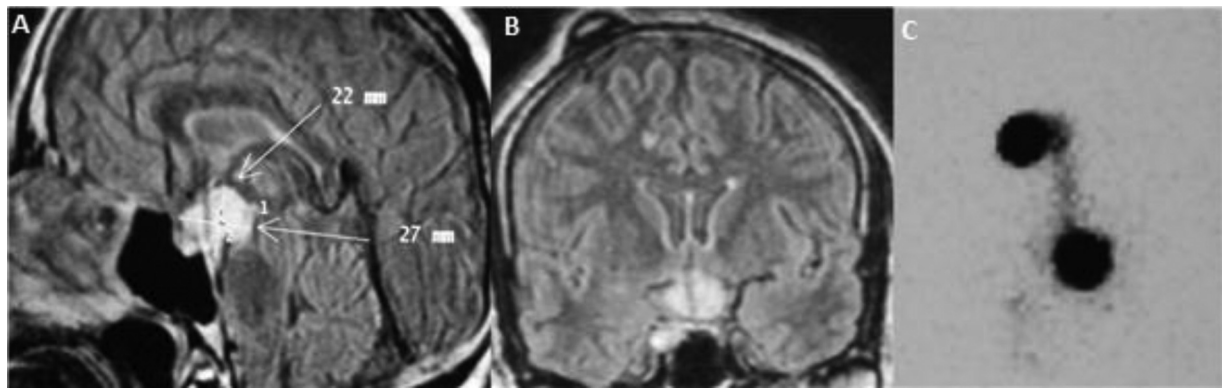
Sagittal (A) and coronal (B) views of an MRI scan showing the satisfactory position of the intracystic catheter. And a gamma-camera control image without leakage of the radioisotope (C).
